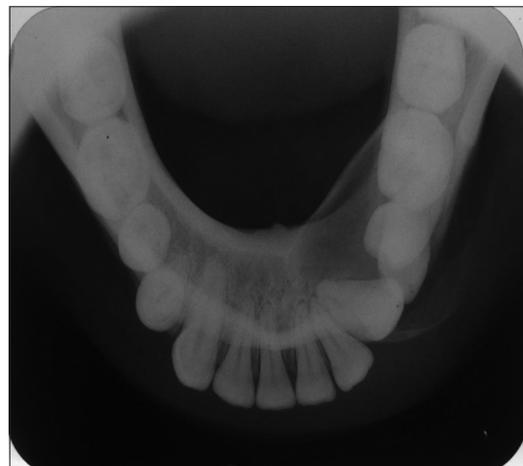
Occlusal radiograph showing bicortical expansion.
